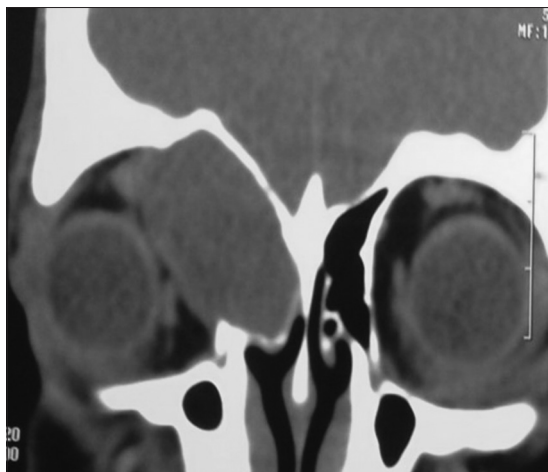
CT scan of the paranasal sinus (coronal view) showing right frontoethmoidal mucocoele. CT: Computed tomography
